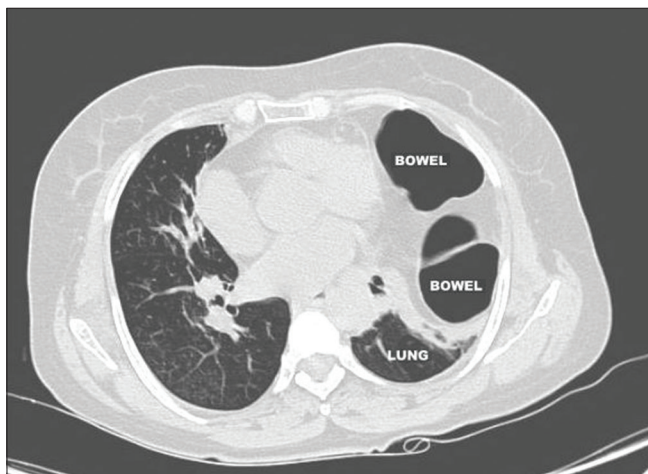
Computed tomography thorax showing left side diaphragmatic injury with bowel herniation
